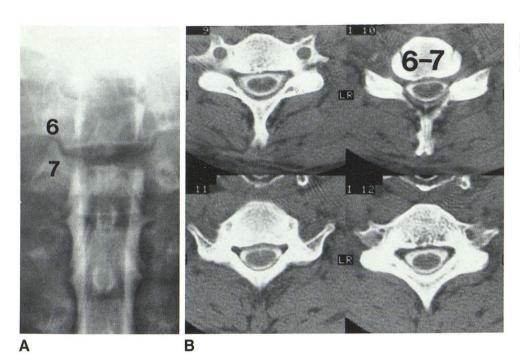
C6–C7 HNP. A, Metrizamide myelogram shows bar defect at C6–C7 with amputation of nerve root sleeves bilaterally. B, Supine CT metrizamide myelogram underestimates findings.
